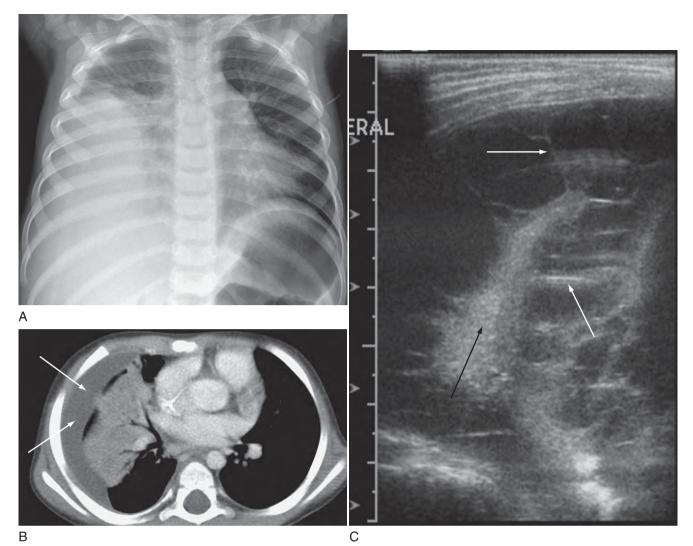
Utility of ultrasound: a 2-year-old boy with hypoxia and fever. Radiograph (A) demonstrates homogeneous opacification of the lower right chest. A CT scan (B) demonstrated a simple-appearing pleural effusion (*white arrows*) in the right hemithorax. Ultrasound examination (C) demonstrated the consolidated lung (*black arrow*) surrounded by fluid that contains many septations (*white arrows*), indicating that this was a complex effusion.
